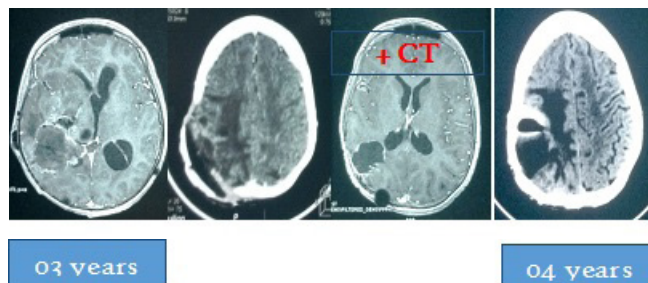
Post-surgical cerebral CT scan and MRI of a 10-year-old patient operated in 2014 for a Parieto-occipital glioblastoma, these images allow the assessment of the nature of the surgical excision, after radiotherapy and chemotherapy.
